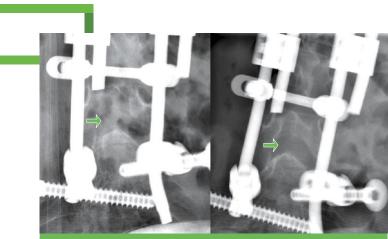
Pre-lumbar puncture X-rays
